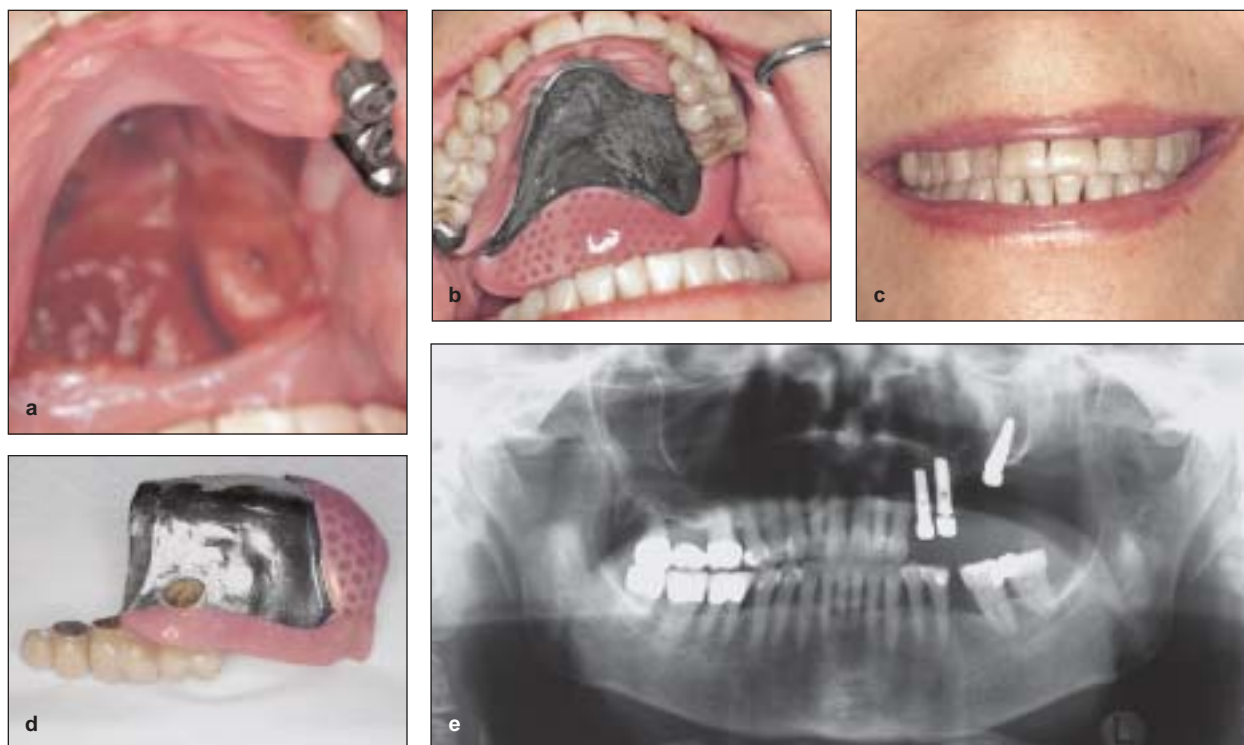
Patient 5: (a) the defect situation after tumor removal and overloading of the left first and second premolars, which were splinted by the former prosthetic restoration and replaced by regular dental implants. These were substituted by a zygoma implant at the left first molar region; (b) the prosthesis in place; (c) occlusal view of the prosthesis; (d) the obturator after 7 years in use; and (e) post-operative radiograph.
